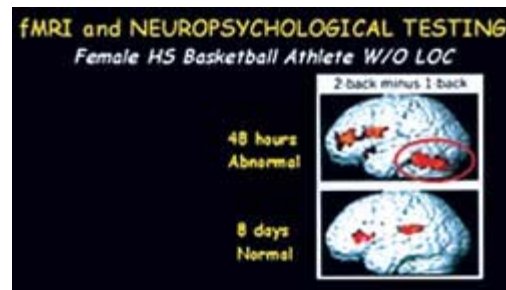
Functional MRI of the brain at 48 hours and 8 days post-injury. At 48 hours, the athlete demonstrates abnormal activation in the cerebellum. Brain activity returns to normal by 8 days, as does neuropsychological test performance.
